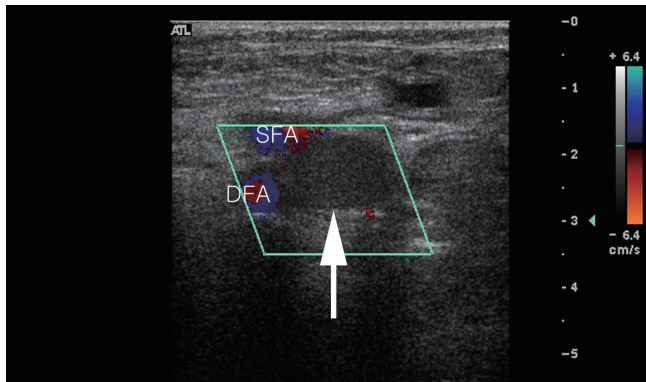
Doppler ultrasonography shows a hypoechoic (not anechoic) mass compressing the right common femoral vein (white arrow). Note that there is no color signal that would suggest the presence of blood flow. The two color signals by the mass represent superficial (upper) and deep femoral artery (lower).
